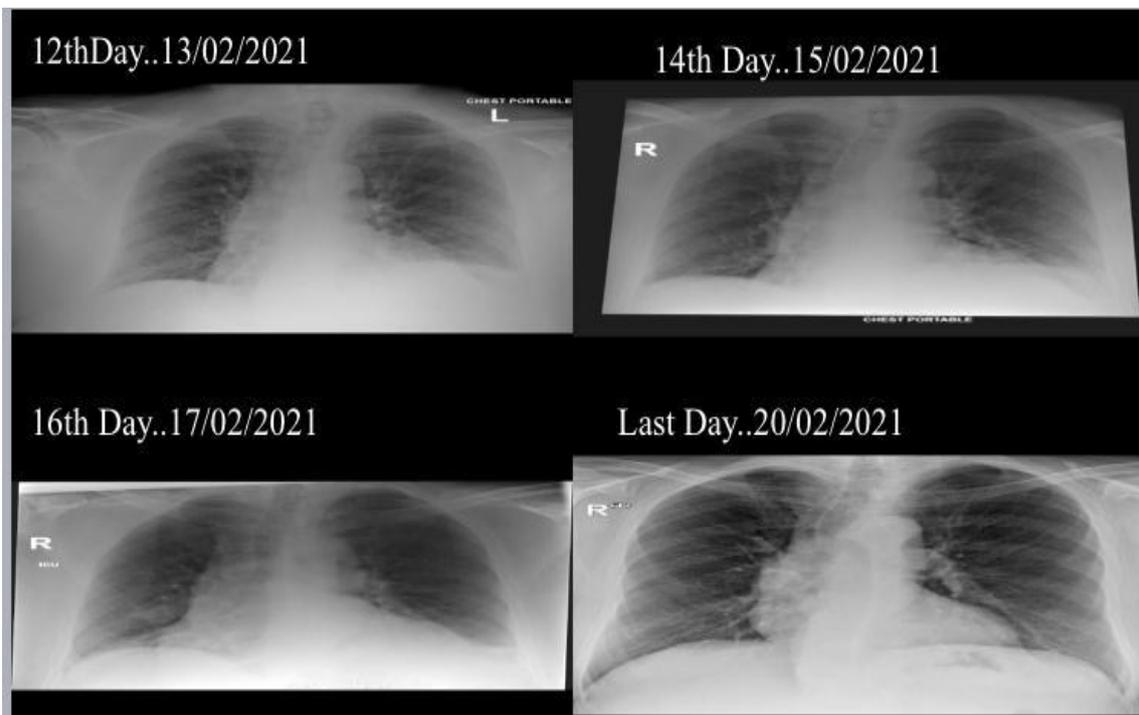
Serial chest x-ray on 12th 14th, 16th, and last day
